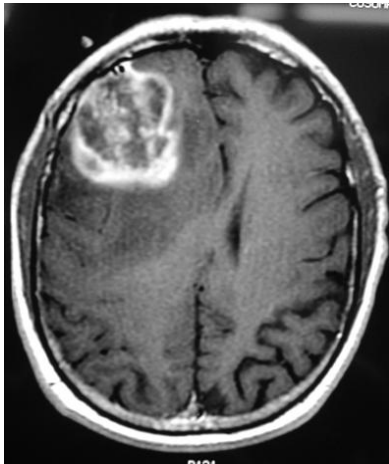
MRI image of glioblastoma
